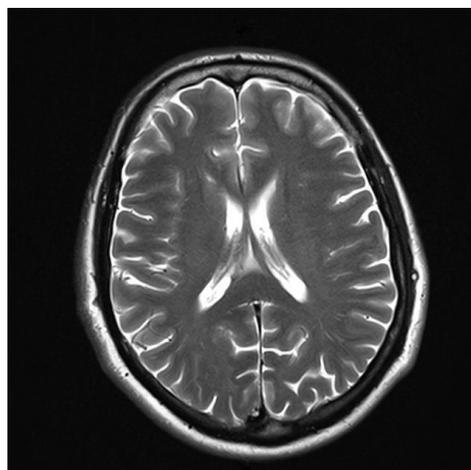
Brain MRI: grade I cortical atrophy, no signs of focal or diffuse cerebral pathology
